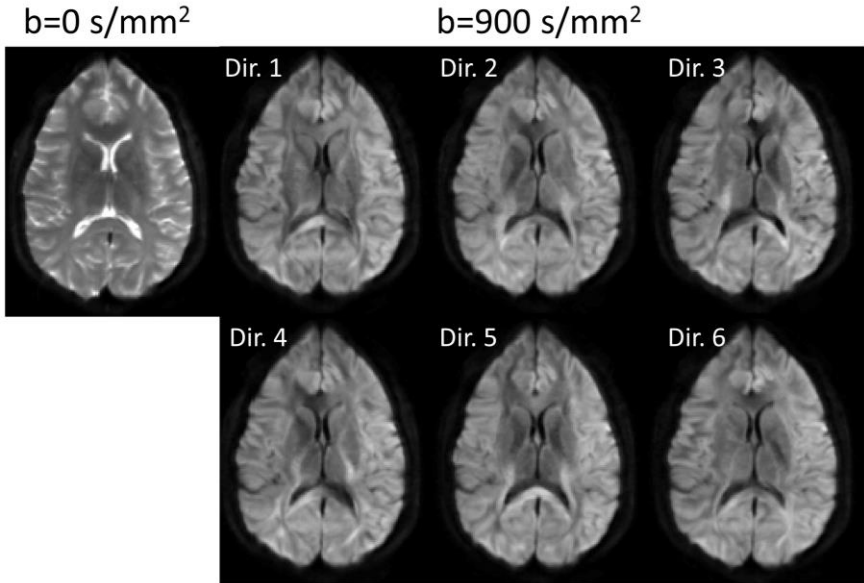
Brain DWI. Magnitude images of a healthy volunteer encoded with six different diffusion gradient directions are displayed. Note the different contrast in the central region of the brain where the magnitude is varying under different gradient directions, indicating diffusion anisotropy.
